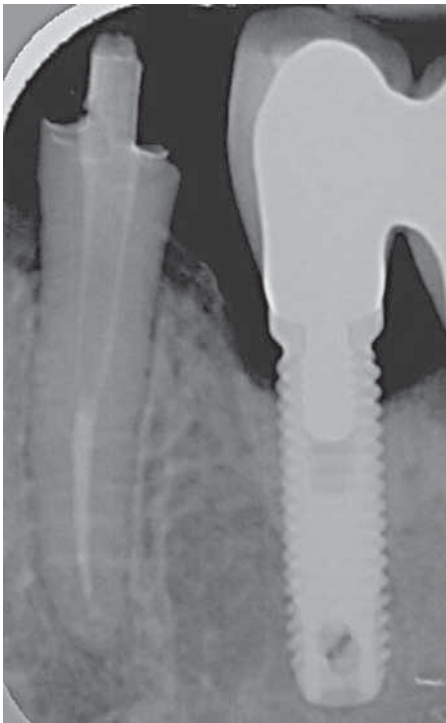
Final radiograph showing the cemented post following the crown preparation.
